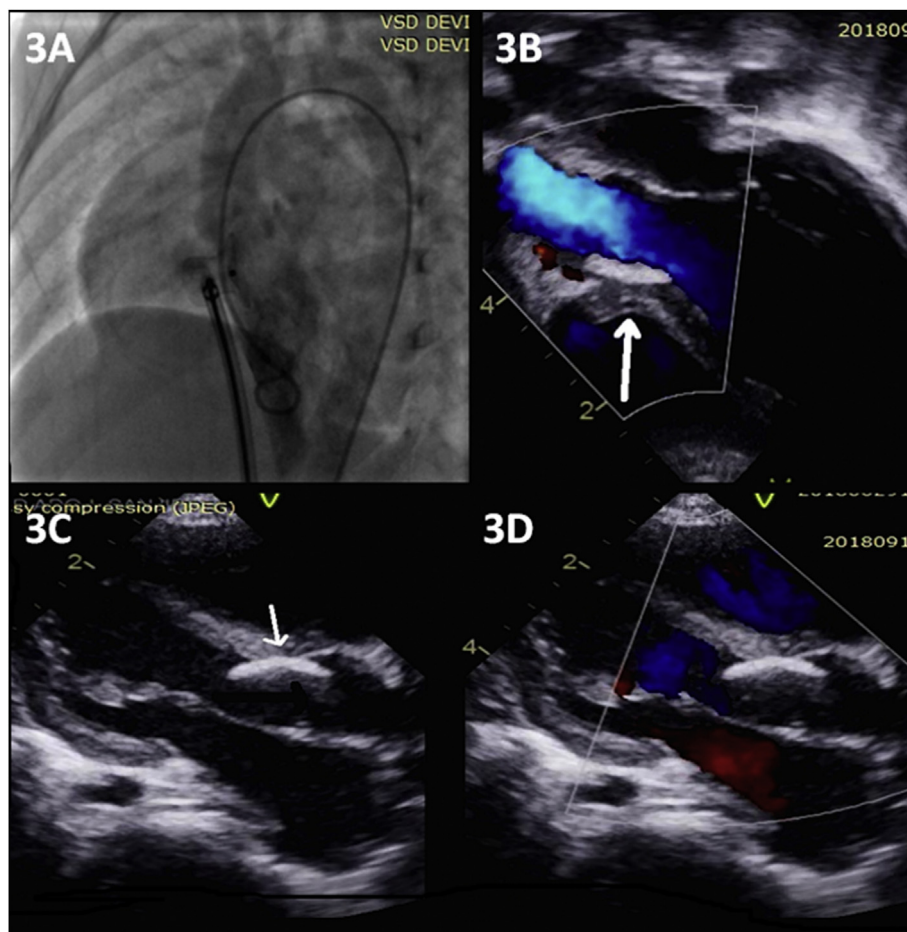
Post device closure assessment- LV angiogram showing stable device position away from aortic valve without any significant residual (3A), Color Doppler echocardiography Apical five chamber view in systole showing device in stable position (white arrow) without causing any LV outflow obstruction (3B), 2D echocardiography Parasternal long axis view showing device (White arrow) away from aortic valve without hampering its coaptation (Black arrow) (3C), Color Doppler echocardiography Parasternal long axis view in diastole showing device not causing any aortic regurgitation(3D).
